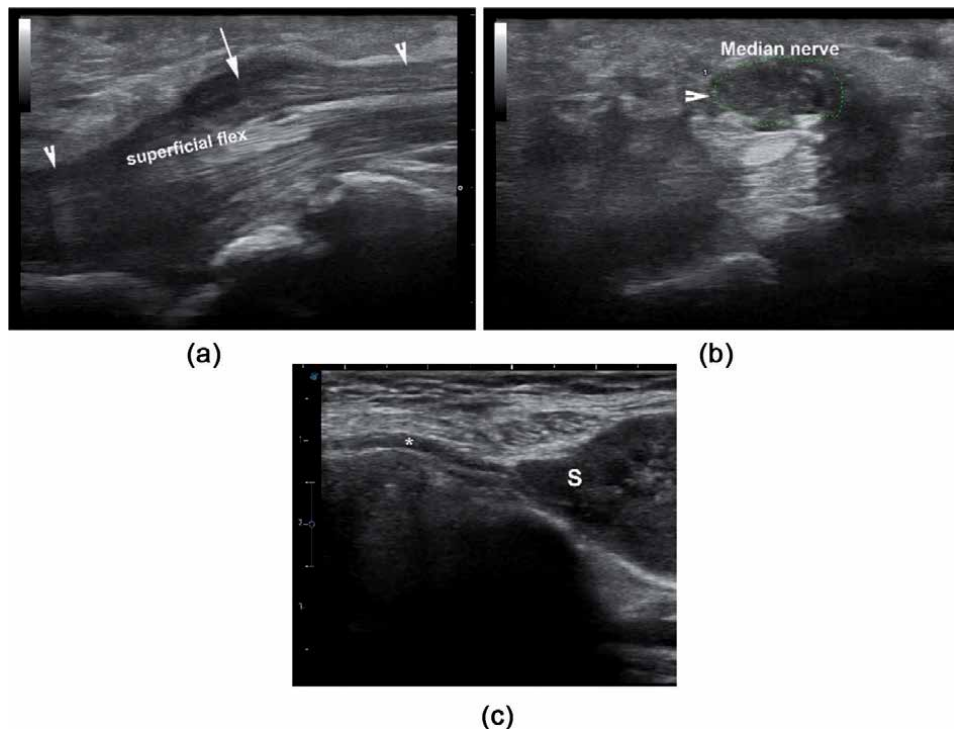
Ultrasound GS images of a median nerve neuroma (a – Longitudinal, b - transverse) and a peroneal schwannoma (c - longitudinal). Arrowhead – Median nerve, arrow – Neuroma, asterisk – Peroneal nerve, S – Schwannoma.
